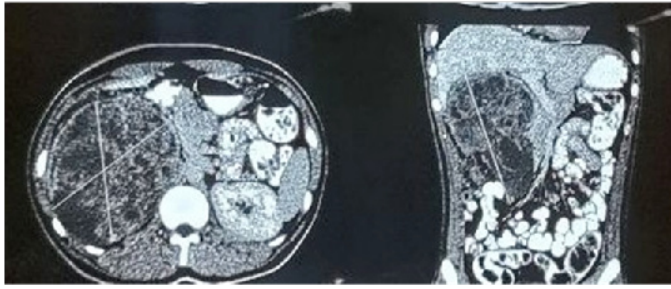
Preop CT images showing the extent of the mass.
